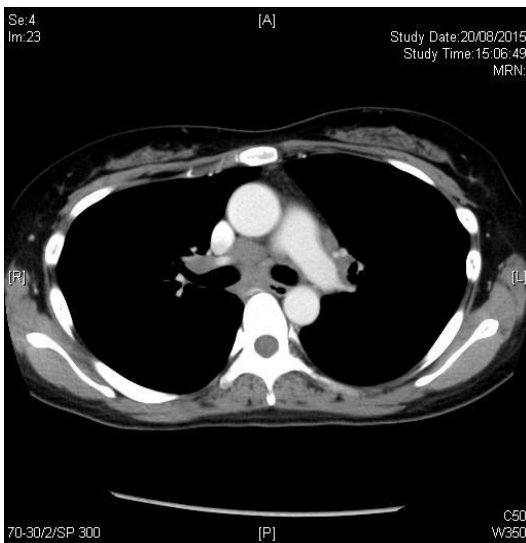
CT thorax (soft tissue window)
